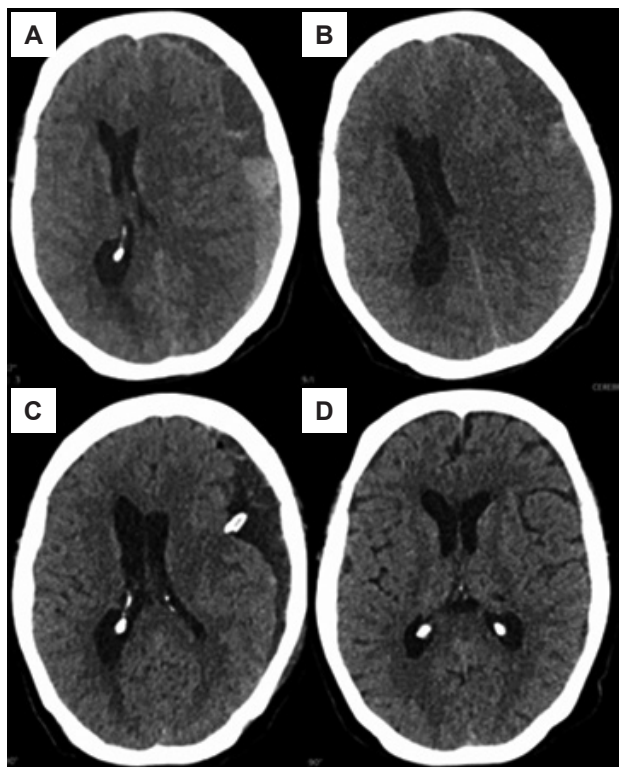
A: Non-contrast axial brain CT performed on the second day after admission showing a left frontoparietotemporal subacute subdural hematoma with rebleeding, measuring approximately 19 mm in thickness and causing significant mass effect with a midline shift of up to 15 mm. B: Follow-up non-contrast brain CT obtained on the tenth day after admission showing progression of the left frontoparietotemporal subdural hematoma, with increased thickness to approximately 22 mm and persistent midline shift, consistent with worsening intracranial mass effect. C: Immediate postoperative non-contrast brain CT performed after trepanopuncture with evacuation of the subdural hematoma and placement of a left frontoparietal subdural drain, demonstrating marked reduction of the hematoma and improvement of mass effect compared with preoperative imaging. D: Follow-up non-contrast brain CT obtained approximately 8 weeks after surgery, demonstrating near-complete resolution of the left frontoparietotemporal subdural hematoma, with restoration of midline structures and no residual mass effect.
